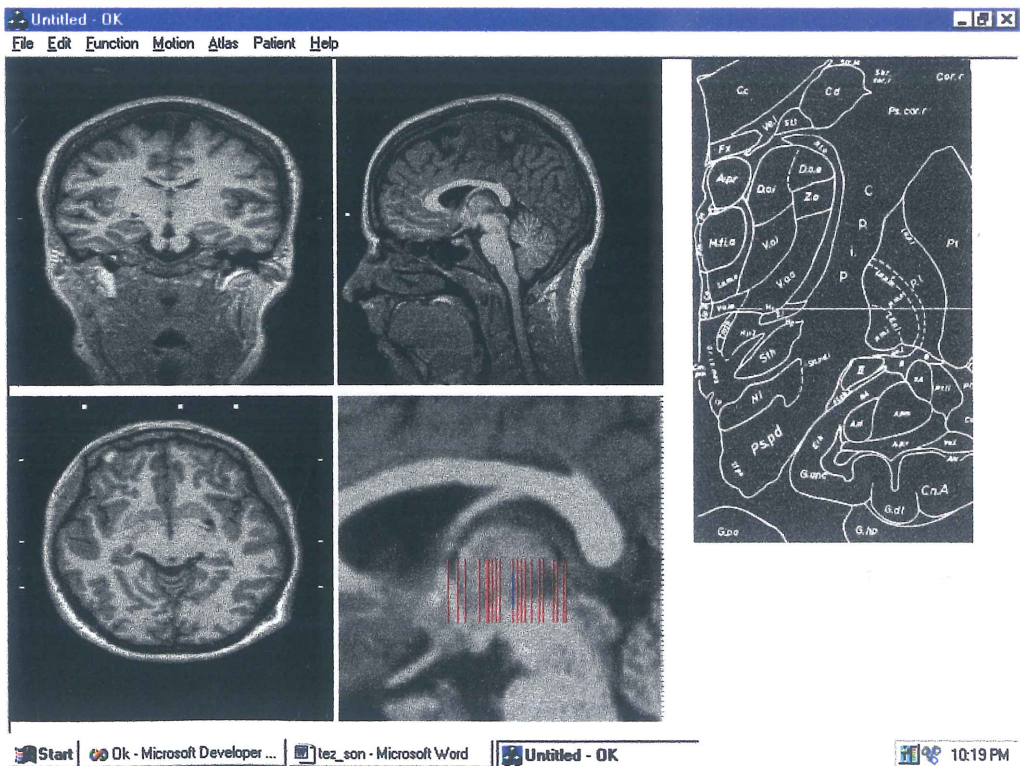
The case with zooming factor of 4 with red lines showing the places of frontal atlas overlays placed on sagittal CT image.
